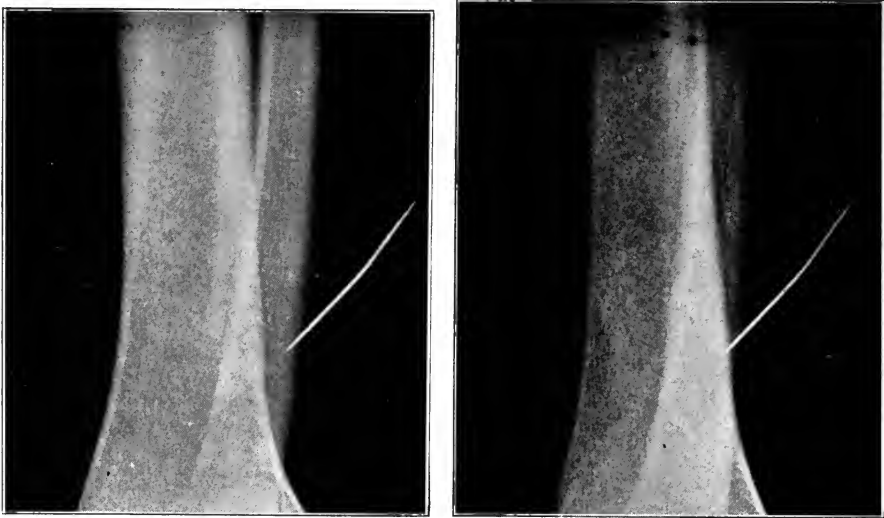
STEREOSCOPIC X-RAY PICTURES OF A NEEDLE EMBEDDED IN THE SOFT PARTS OF A MAN'S LEG. If these pictures be viewed through an ordinary refracting stereoscope, the relation of the needle to the bones can be plainly seen. (Author's collection.)
